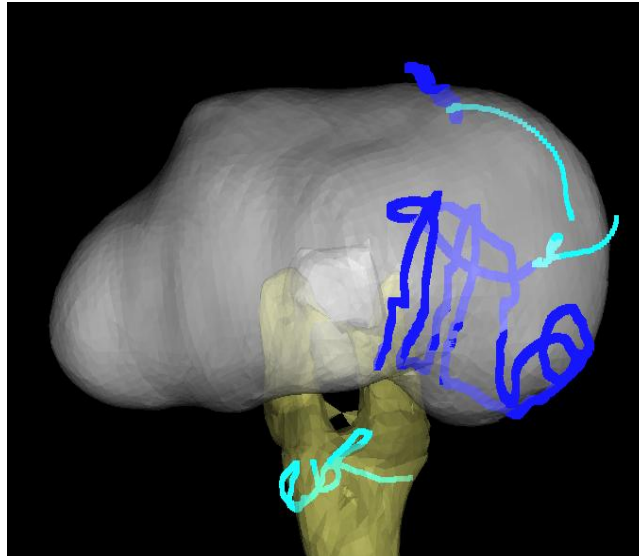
The dark blue lines were used for registration with the CT image. Cyan areas of the kidney and on the hilum were not used to create transformation matrix. Registration was applied to held-out kidney and hilum data.
